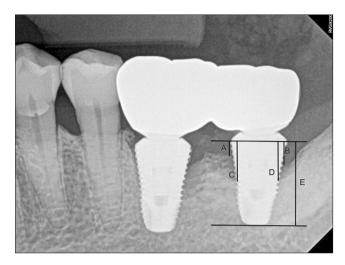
Landmark of the periapical radiograph. A: marginal bone level of the mesiobuccal aspect, B: marginal bone level of the distobuccal aspect, C: marginal bone level of the mesiolingual aspect, D: marginal bone level of the distolingual aspect, E: length of the implant on the periapical radiograph.
